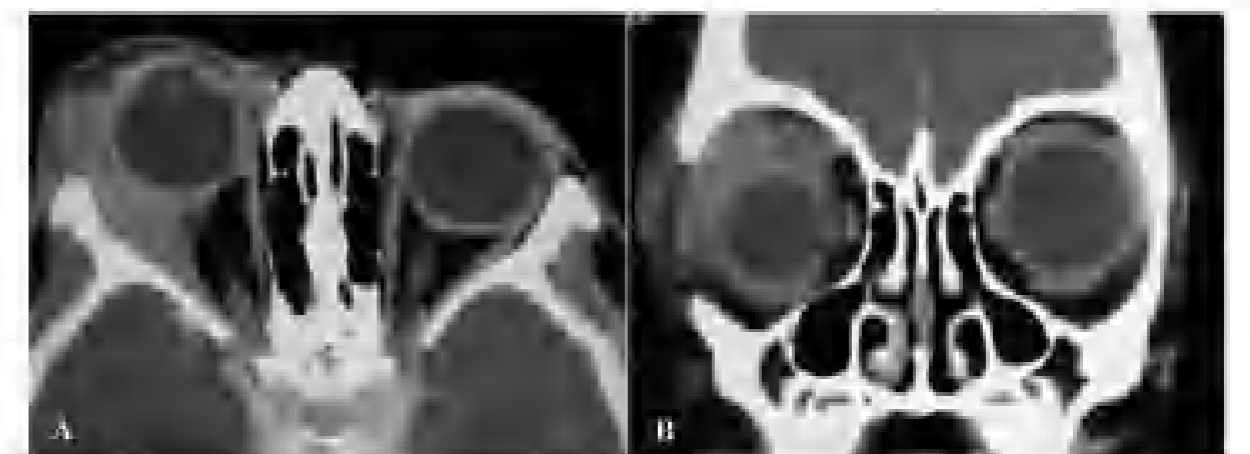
Axial CT scan of the head showing a 4 × 4 mm (gray) nodule in the right superior part of the eye (A) and normal (B) views.
